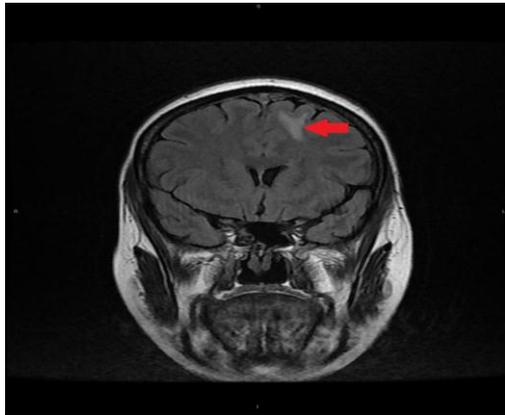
MRI Brain Acute Left Temporo-occipital Infarction
